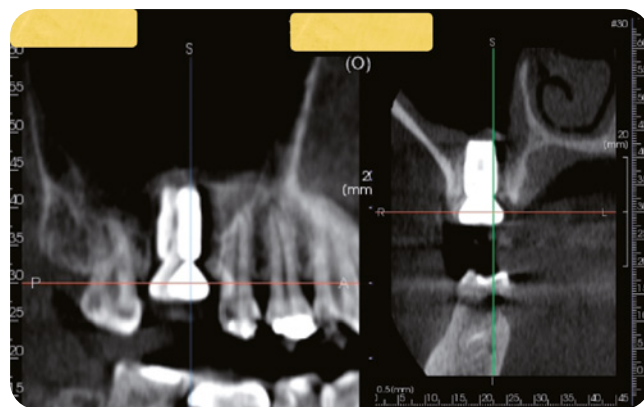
Postoperative CT scan showing bone graft intact under the Schneiderian membrane.
